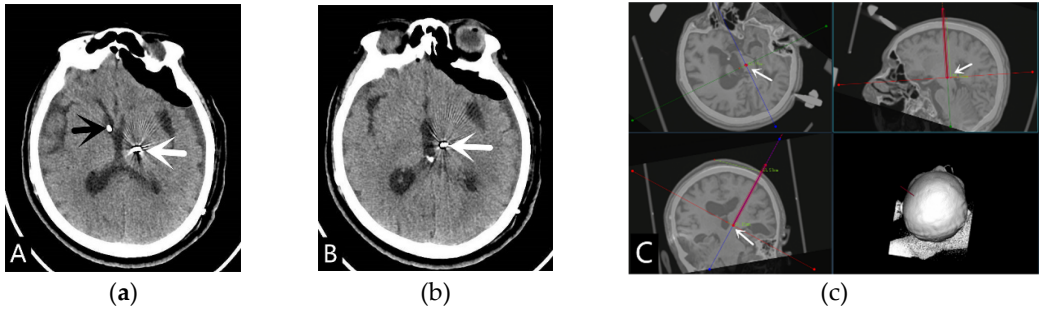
A stroke patient with secondary hydrocephalus underwent VPS and DBS surgery:(a)Placement of left DBS (white arrow)and right ventricular shunt(black arrow) simultaneously during surgery;(b)Fusion of CT and MRI images before DBS surgery, locating the left CM-pf nucleus(white arrow);(c)The end of the DBS electrode is located in the left CM-pf nucleus region(white arrow).
